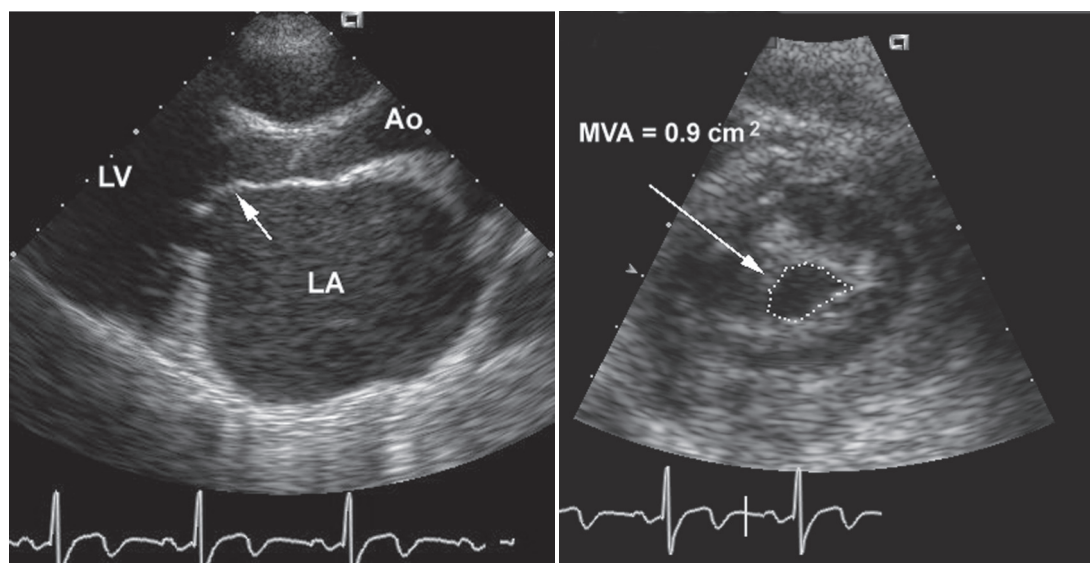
Parasternal long-axis (left) and short-axis (right) two-dimensional echocardiographic views showing the characteristic findings in rheumatic MS. Note the commissural fusion that results in doming of the leaflets in the long-axis view and in a decrease in the width of the mitral orifice in the short-axis view. The patient has relatively thin, flexible leaflets with little subvalvular involvement. Ao = aorta; LA = left atrium; LV = left ventricle. (From Otto CM: *Valvular Heart Disease*. Philadelphia, Saunders, 2004.)
